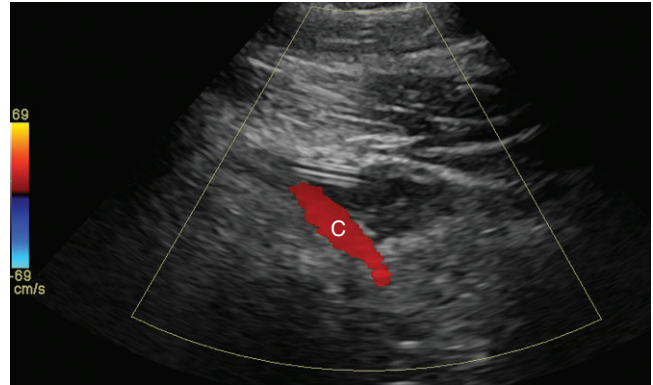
Long axis color Doppler of the subclavian vein. There is occlusion of the vein at the site of thrombosis. A collateral vein (C) is flowing toward the midline. It is a collateral vein since it does not have the expected course paralleling the subclavian artery.
